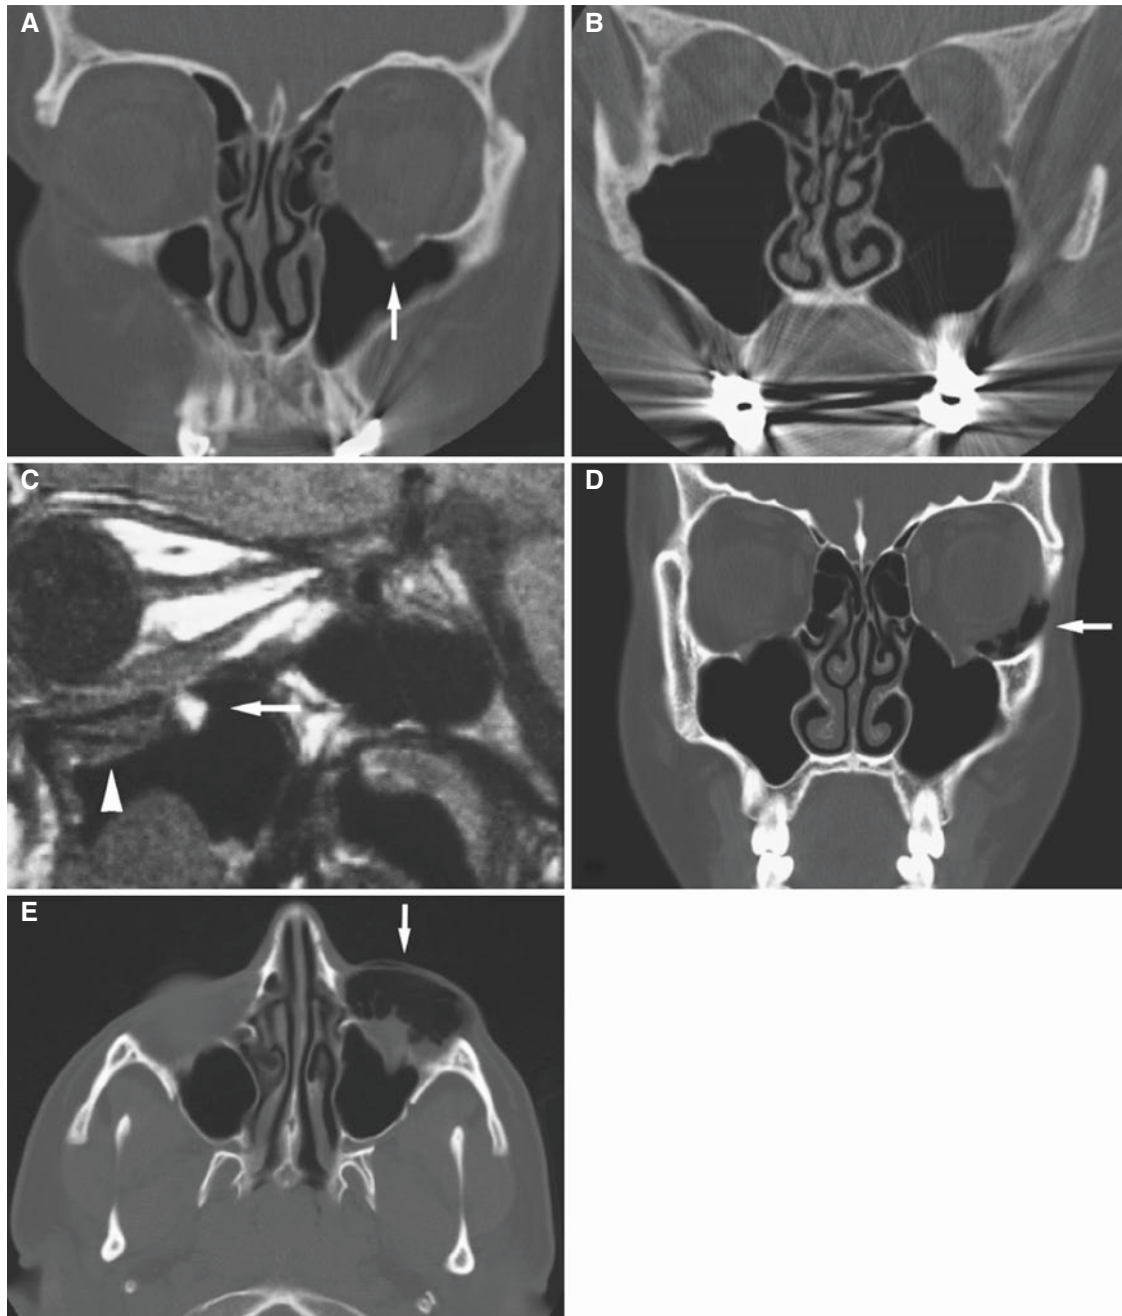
Blowout fracture, classic; 60-year-old female with fall on the face 10 days previously, with infraorbital hematoma and some tenderness. (A) Coronal CT image shows fracture of orbital floor (*arrow*). (B) Coronal CT image, more posterior section, shows otherwise normal sinuses. (C) Sagittal MRI of another patient shows orbital fat (*arrow*) and bone fragment and mucosal swelling or muscle tissue (*arrowhead*)
